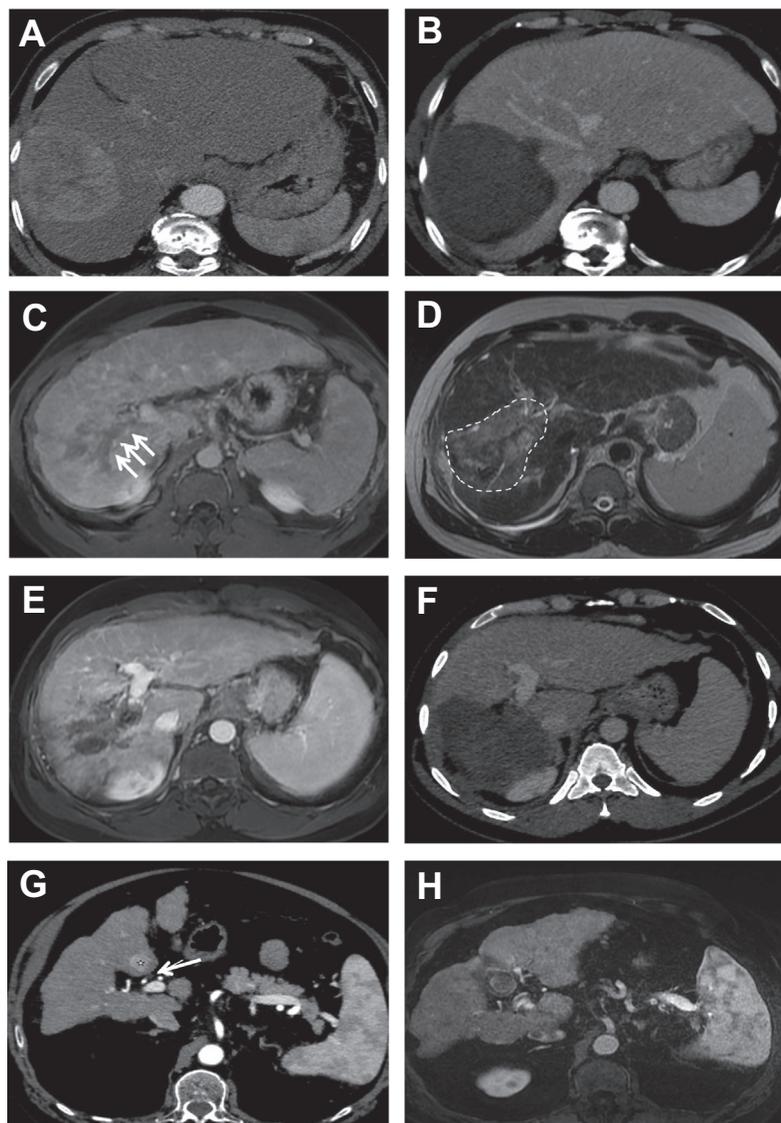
Examples of extension of ablation criteria. Case 1: Large single 8.5 cm HCC in the right hepatic lobe in a 50-year-old man with hepatitis B cirrhosis (A). Surgical resection was contraindicated because of severe portal hypertension. The patient was finally treated with multipolar RFA. Portal phase CT images after two multipolar RFA sessions showed complete ablation with a large necrotic unenhanced area encompassing the targeted tumour (B). Case 2: Infiltrative HCC and vascular invasion in a 42-year old man with hepatitis B cirrhosis (BCLC C). MR images showed an infiltrative pattern of the right liver with tissular hypervascular tumour thrombus (arrows) in the right portal branches (C). Note that the head of the thrombus is located at the ostium of the right portal branch. Irreversible electroporation (IRE) of the head of the thrombus was performed first in order to stop vascular invasion and to avoid contralateral tumour dissemination. One-month post-IRE, MR images showed the electroporated area (dotted lines) with T2 hyperintensity (D). Note devascularisation of tumour thrombus on contrast-enhanced MR images (E). Large multipolar RFA of the remnant right liver was subsequently performed. Follow-up CT images (F) showed complete destruction of the right liver, with patency of the main and left portal veins. More than 1 year after the first IRE, the patient was alive without a detectable tumour. Case 3: A 71-year-old man with alcoholic cirrhosis and 2 cm typical HCC at the arterial phase of the CT scan (star) (G). The lesion was located at the hilar side of segment IV, in contact with the main bile duct (arrow), the reason for choosing IRE in this case, which is a contraindication for thermal ablation. One month post-IRE, MR images showed T1 hyperintensity of the treated tumour, without residual arterial enhancement (H), along with T2 hypo-intensity indicating complete treatment. After 20 months of follow-up, the patient was tumour-free and the main bile duct was not enlarged or narrowed. CT, computed tomography; HCC, hepatocellular carcinoma; IRE, irreversible electroporation; MR, magnetic resonance; RFA, radiofrequency ablation.
